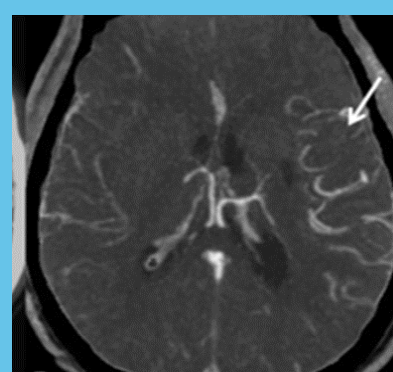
CT angiogram image in patient with a left MCA clot shows good collateral blood flow in the left MCA distribution.
